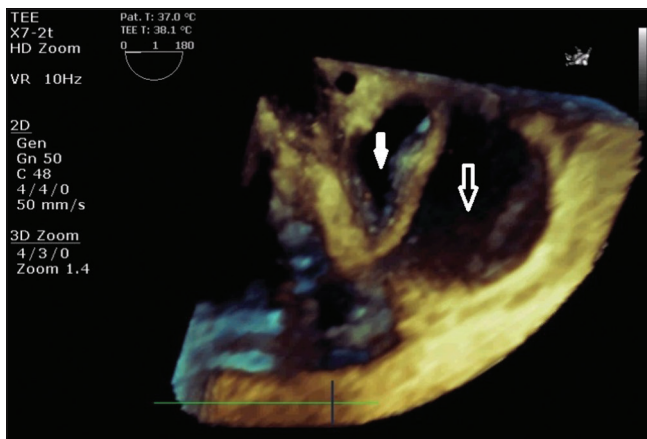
Three-dimensional echocardiographic image of descending aorta SAX view demonstrating true lumen (white arrow) and false lumen (black arrow)
